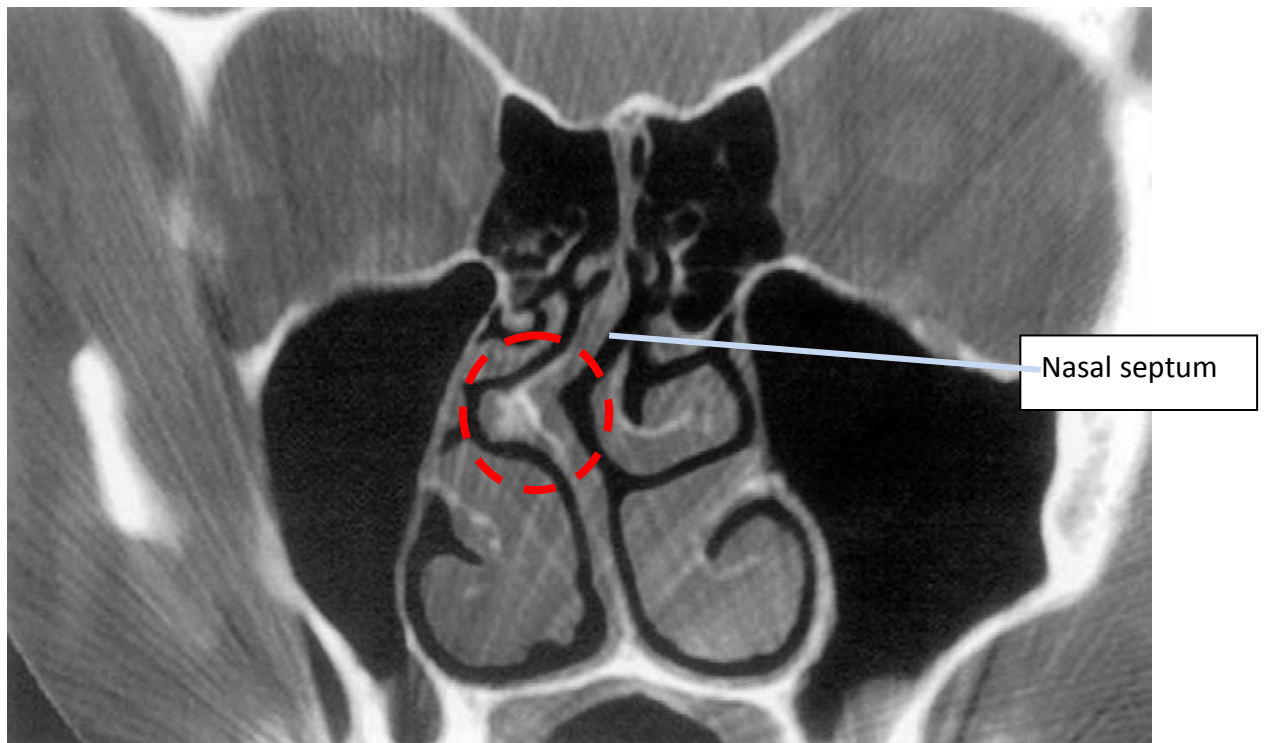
CT scan PNS (coronal view) showing a deviated nasal septum. (Adopted from James NP *et al*, 2013)
